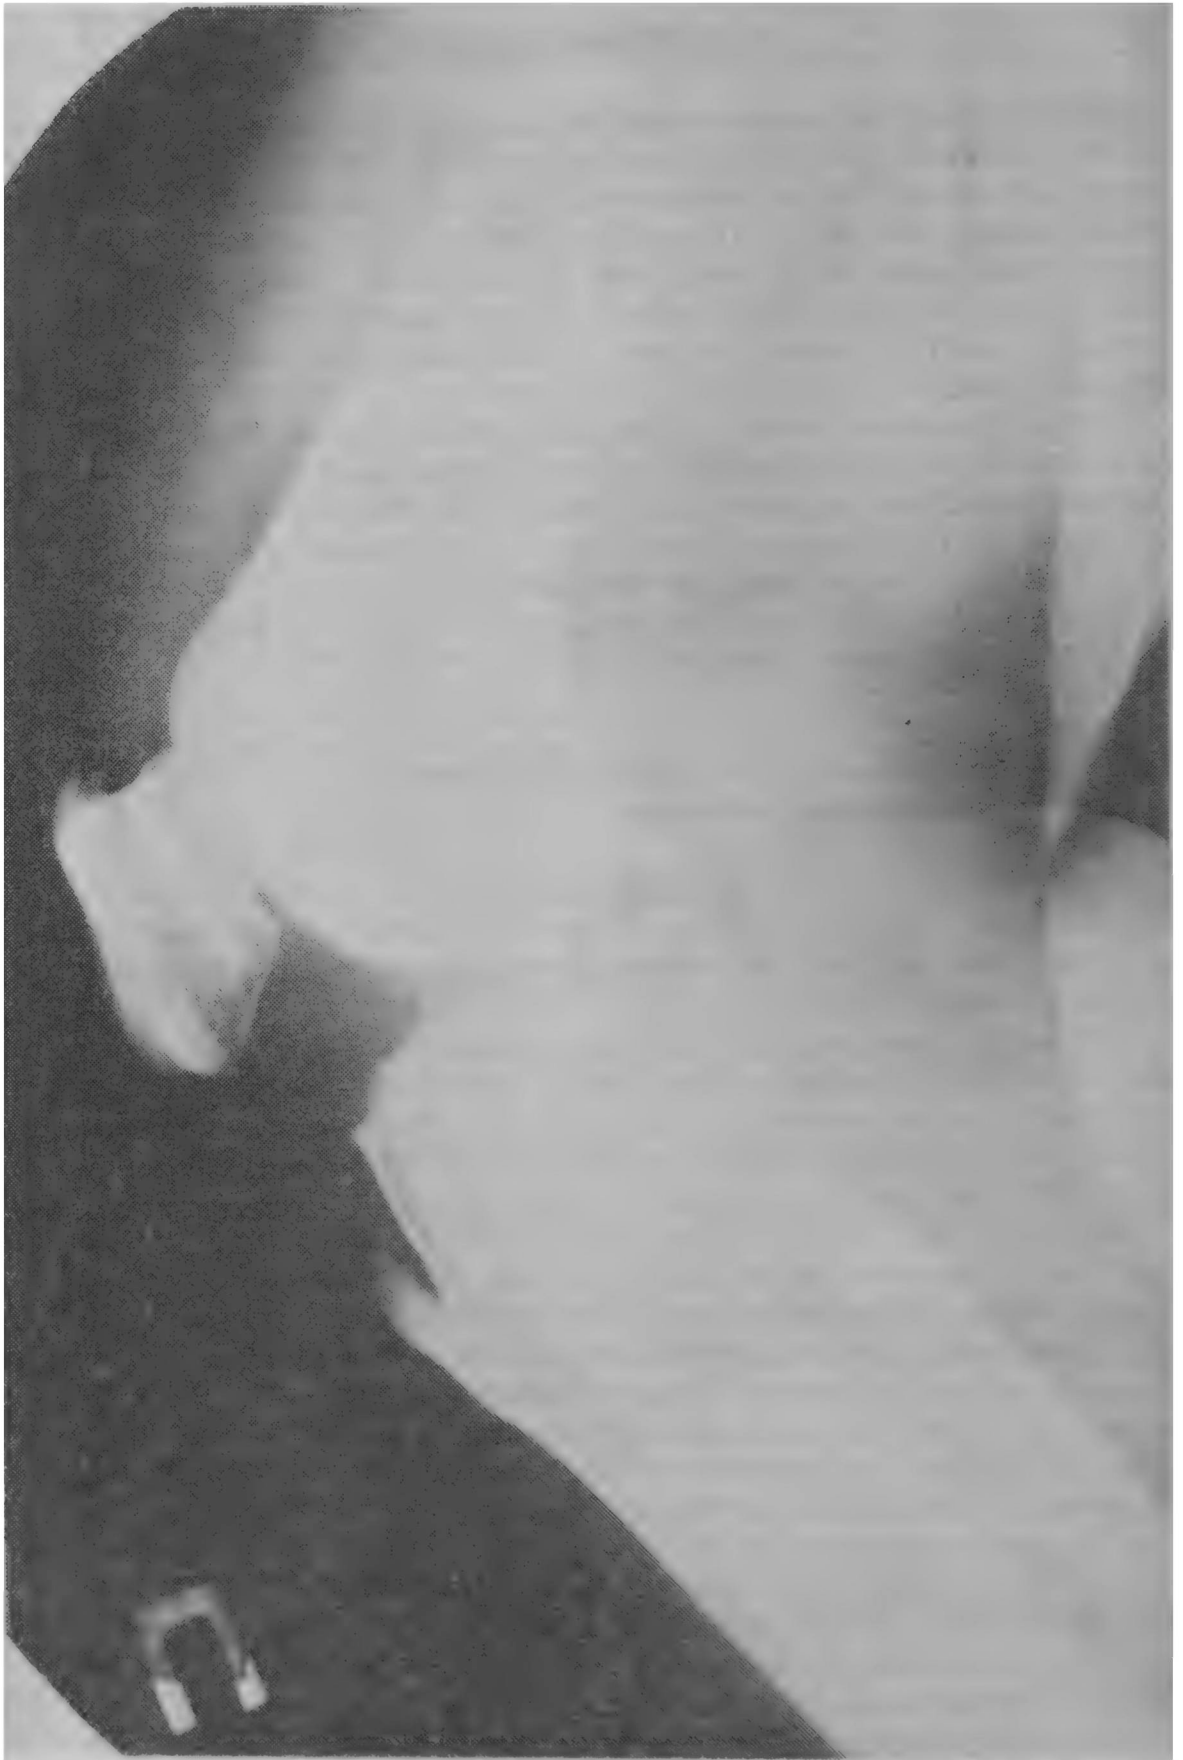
X-ray of patient with Osgood-Schlatter disease (the right tibia) in patient K, 21 years.
